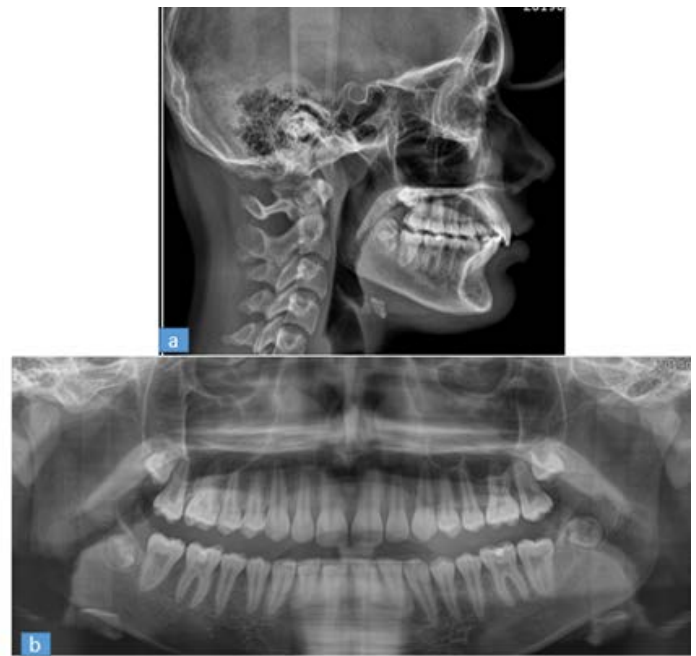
Post Treatment (a) Lateral Cephalogram (b) Orthopantomogram
